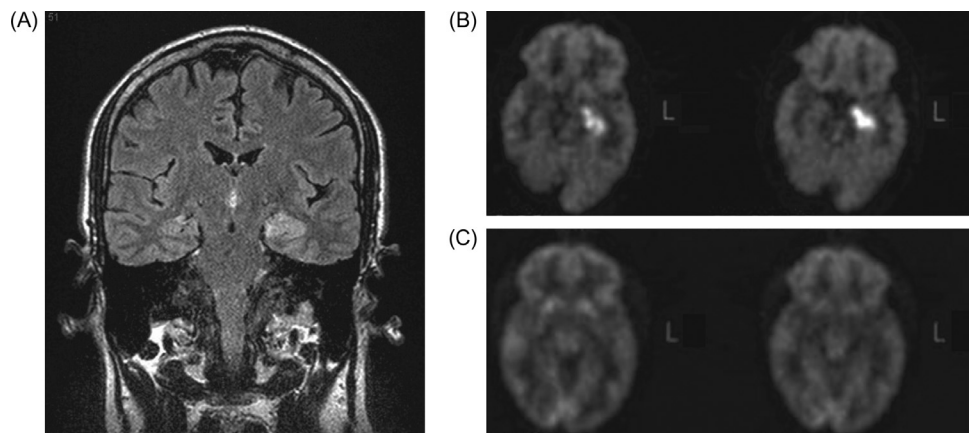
Neuroimaging during a prolonged episode of transient epileptic amnesia. (A) FLAIR MRI scanning during a prolonged episode of transient epileptic amnesia revealed hyperintensity in the left hippocampus. (B) FDG-PET scanning during the same episode showed hypermetabolism localized to the left anterior hippocampus. (C) This region had returned to normal 1 month later.
